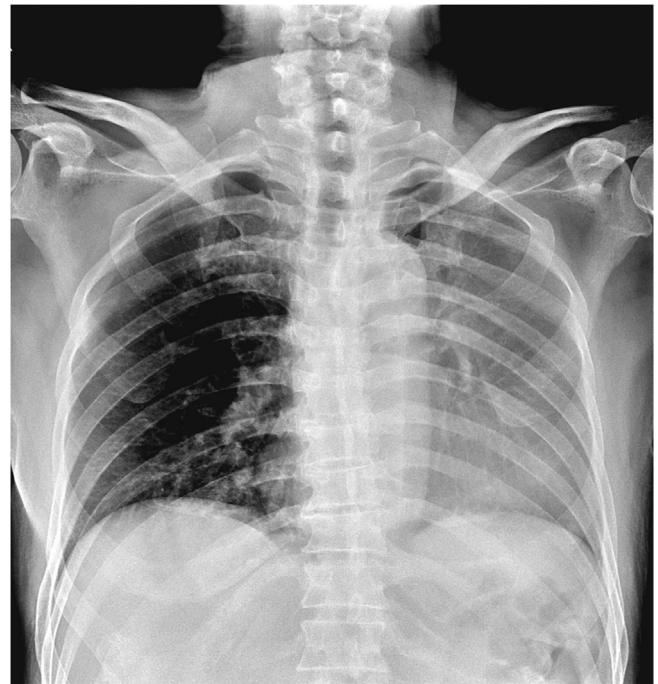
Chest X-ray showed consolidation in the left lung field.
